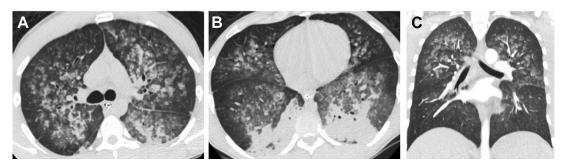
(*A*, *B*) A 33-year-old homeless man who presented with respiratory failure bloody secretions. He was a regular cocaine user and admitted to recently smoking heroin before admission. CT images show symmetric groundglass opacities, dependent consolidation, and smooth interlobular septal thickening. These findings were believed to represent a combination of permeability edema and hemorrhage in the context of bloody secretions. (*C*) A 24-year-old man who presented with lung injury from smoking the gel out of a fentanyl patch. He was hypoxic to 89% on room air and coughing up blood at the time of presentation. CT was negative for pulmonary embolism but showed symmetric bilateral ground-glass opacities attributable to smoking fentanyl. Patient's symptoms improved and he was discharged the following day.
